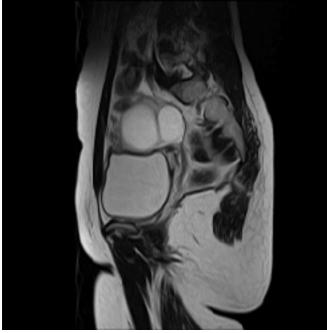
Magnetic resonance images of patient showing right adnexial mass
